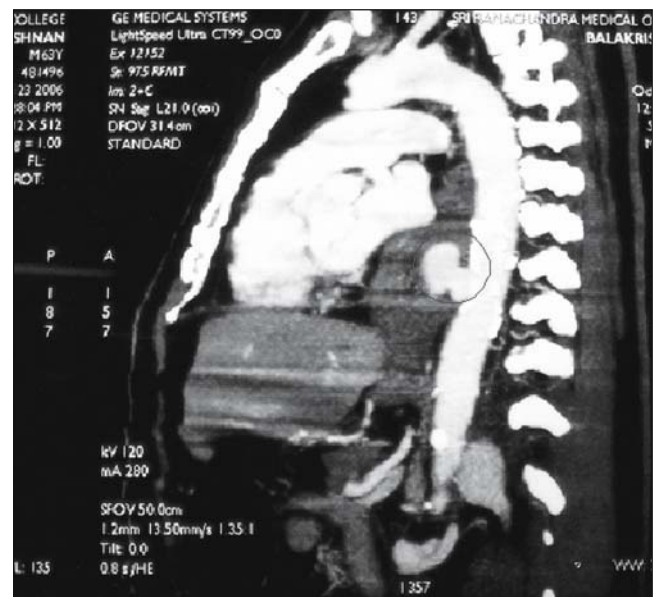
The computed tomography image demonstrating dissection flap in arch of aorta.
